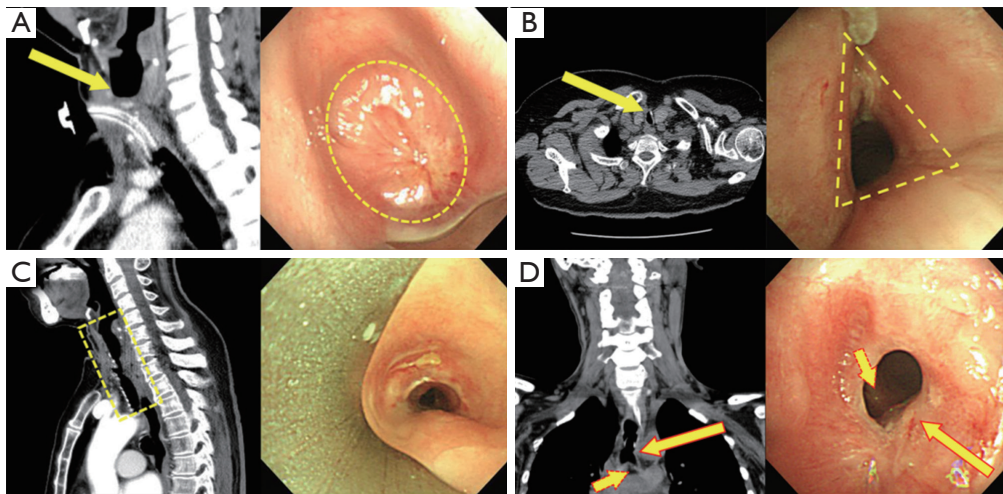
CT and bronchoscopic findings according to PTTS type. (A) Subglottic type. Subglottic area was completely obstructed by fibrotic stricture (arrow and circle); (B) stoma type. Upper trachea at the tracheostomy stoma was narrowed by cartilage fracture and fibrosis (arrow). Tracheal stenosis of triangular shape was observed during the bronchoscopy (dotted triangle); (C) cuff type. Mid-trachea at the cuff level was narrowed by fibrotic bands (dotted square); (D) tip granuloma type. Distal trachea just above the carina was narrowed by fibrosis (long solid arrow: fibrotic band; short dotted arrow: carina). CT, computed tomography; PTTS, post-tracheostomy tracheal stenosis.
